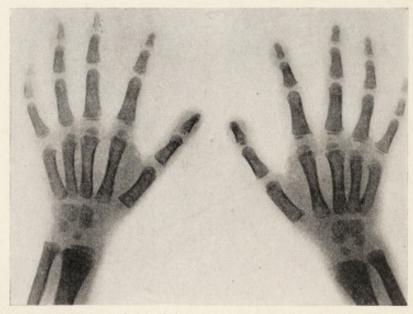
Roentgenogram of clubbed fingers in congenital heart disease, showing normal bones. Same hands as in Fig. 135.
